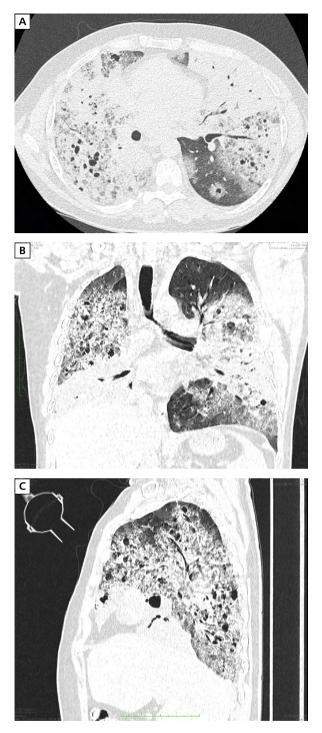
A. Computed tomography (CT) in the axial projection; B. CT in the frontal projection; C. CT in the sagittal projection of the right lung
